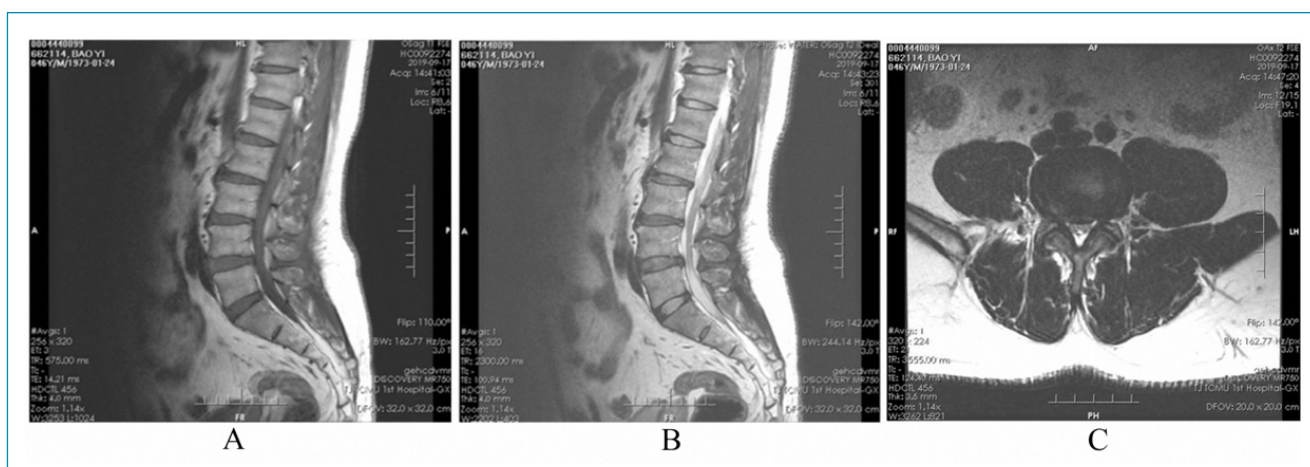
Representative sagittal T1-weighted image: (A) T2-weighted image; (B) and representative transverse T2-weighted image; (C) of the lumbar region by using magnetic resonance scanning obtained from a 46-year-old patient.
